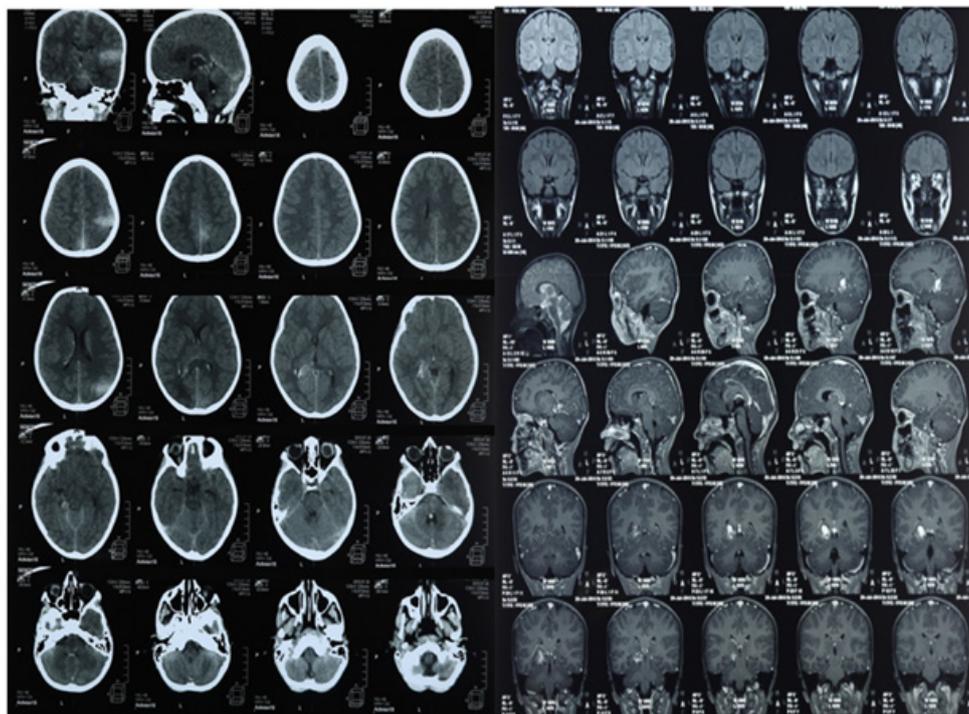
CT with contrast showing an intraparenchymal hemorrhage.
